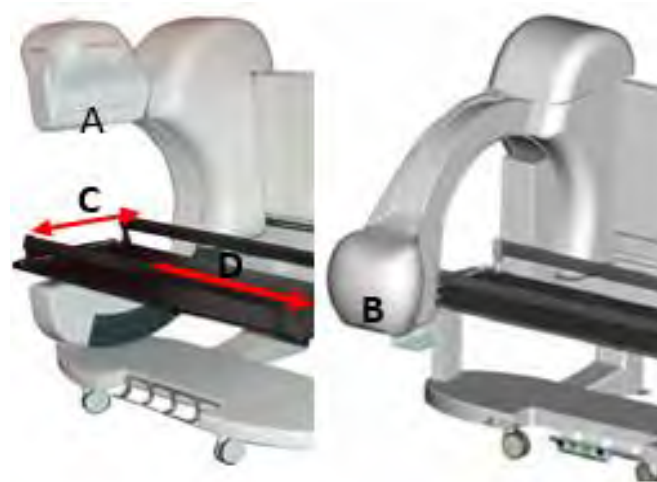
Lodox Statscan: (A) C-arm in vertical position, (B) C-arm in horizontal position, (C) Slit direction and (D) Scan direction. Retrieved June 30, 2016 from <http://radiologykey.com/trauma-radiography/>. Courtesy Lodox Systems [Pty], Ltd.
